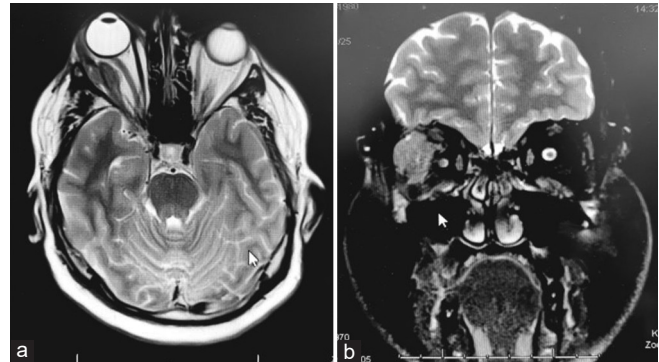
Magnetic resonance imaging scans showing a right orbital mass with intraconal and extraconal components and involving the right lacrimal gland and superior and lateral rectus muscles. (a) T2-weighted magnetic resonance imaging in the axial view. (b) Fat-saturated T2-weighted magnetic resonance imaging in the coronal view
